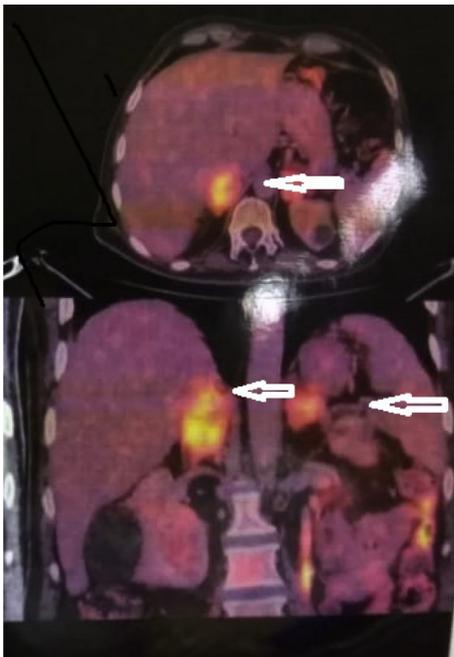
Arrows in PET CT showing FDG-avid uptake in the adrenals and liver. PET CT, positron emission tomography computed tomography.
